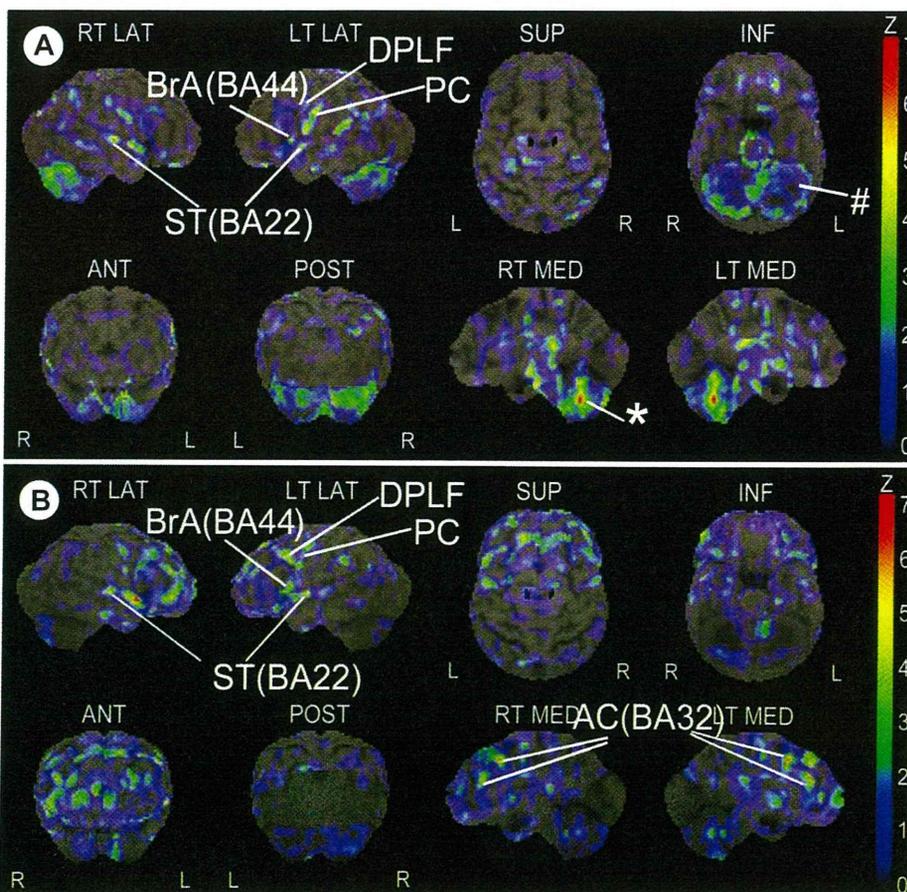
Z-score map computed by iSSP (Interface Stereotactic Surface Projection) application (iNEUROSTAT+) shows increased ^{18}F -fluorodeoxyglucose uptake areas examined by positron emission tomography-computed tomography. A) Subject 1. B) Subject 2. Cortical activity is shown as grading image of more-deviant regions in red (*) and less-deviant regions in purple (#) by pixel. R, RT — right; L, LT — left; LAT — lateral; SUP — superior; INF — inferior; ANT — anterior; POST — posterior; MED — medial; BA — Brodmann area; ST — superior temporal gyrus; DPLF — dorsolateral prefrontal cortex; PC — precentral gyrus; AC — anterior cingulate gyrus.
